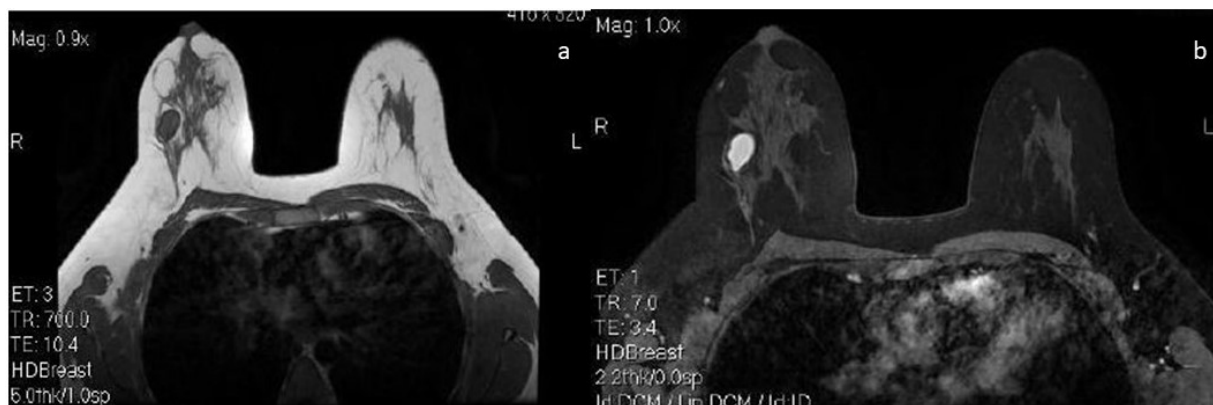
a) T1W MRI without contrast shows an intermediate intensity mass in the upper outer quadrant of the right breast. b) T1W MRI with contrast shows intense rapid enhancement after contrast injection. Since the pseudoaneurysm happened in about 2 cm of the mass, the mass is not obvious in this cut.
